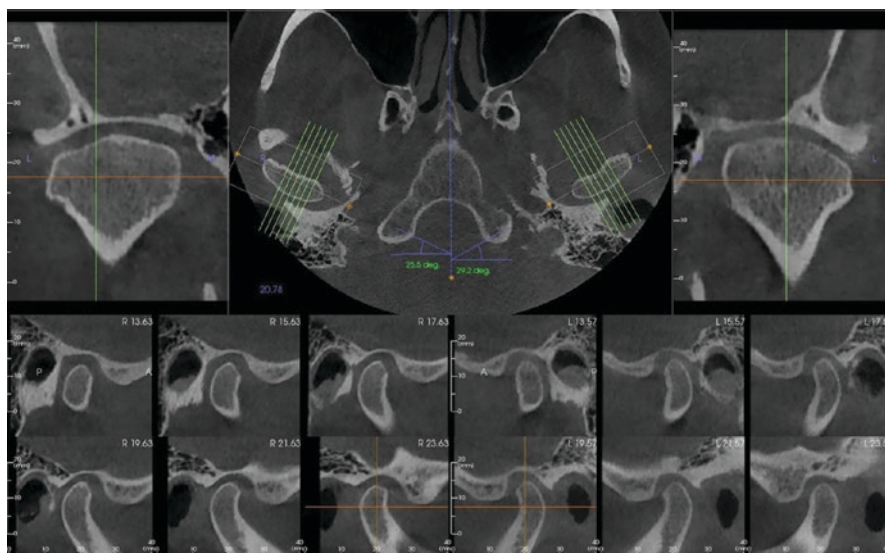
CBCT cross-sectional display of the temporomandibular joints. Reformatting provides serial cross-sectional images of right and left condyles within the same page layout. *Green-red crosslines* provide orientation. *Green lines* correspond to cross-sectional slices
